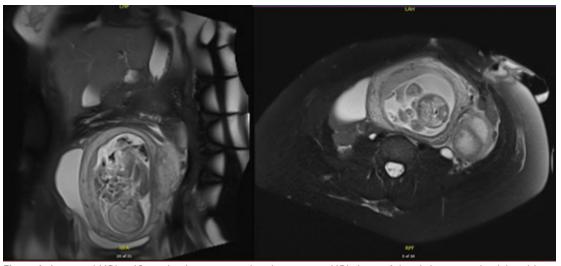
Antenatal MRI at 19 weeks shows coronal and transverse MRI views of the abdomen and pelvis, with a complex multi cystic 5.9cm mass in the left pelvis, may be ovarian in origin. Moderate amount of free fluid, partly septated, in the pouch of Douglas and along the right side of the gravid uterus. No bowel wall thickening. Previous colectomy with left iliac fossa stoma.
